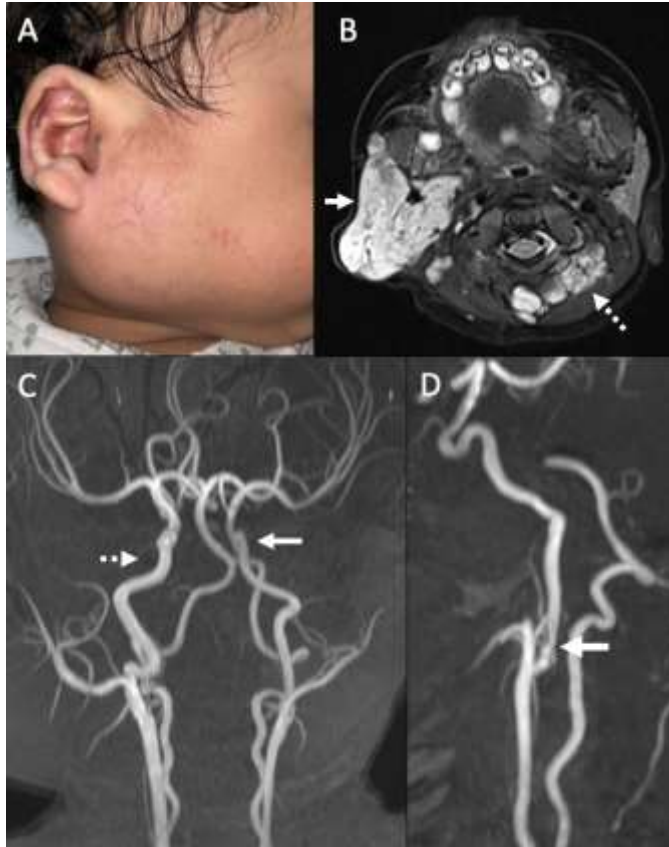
(a) Right cheek swelling with some telangiectatic changes over it. (b) Axial T2-weighted images with fat saturation shows hemangiomas in the right parotid space (solid arrow) and posterior paraspinal muscles (dashed arrow). (c) Maximum intensity projection of time-of-flight MRA shows smaller caliber of the left internal carotid artery (arrow) compared to the right internal carotid artery (dashed arrow). (d) Focal stenosis of the proximal left internal carotid artery just distal to the carotid bifurcation (arrow).
